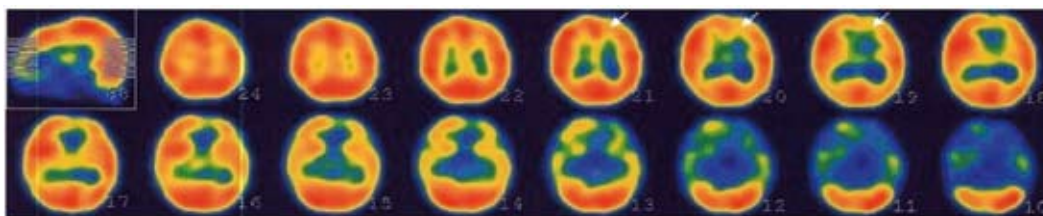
Single photon emission computed tomography (SPECT) of the brain showing significant hypoperfusion in the left frontal cortex (arrows).
